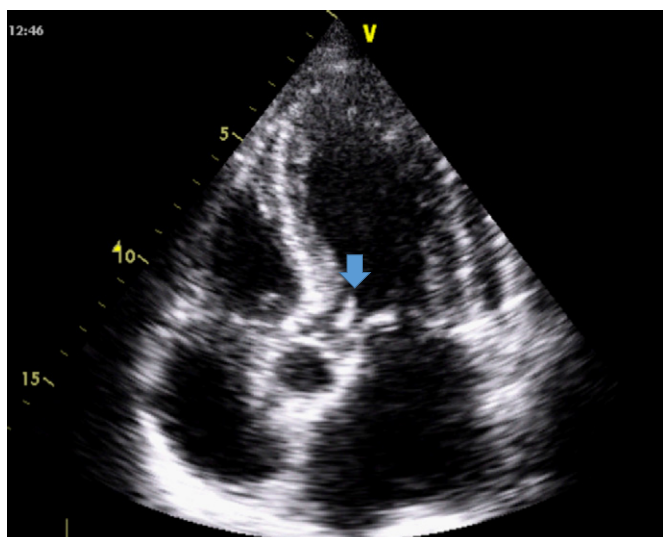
Apical four chamber view of transthoracic echocardiogram showing a mobile formation (arrow) of 2 cm length attached to the non-coronary cuspid of the aortic valve, highly suspicious for endocarditis.
